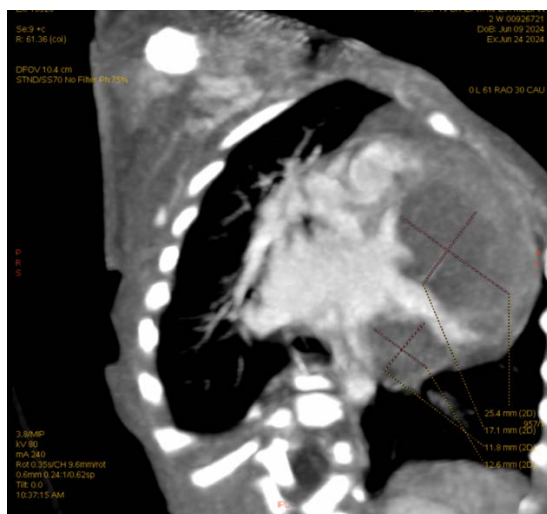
Cardiac CT revealed multiple masses in LV cavity
